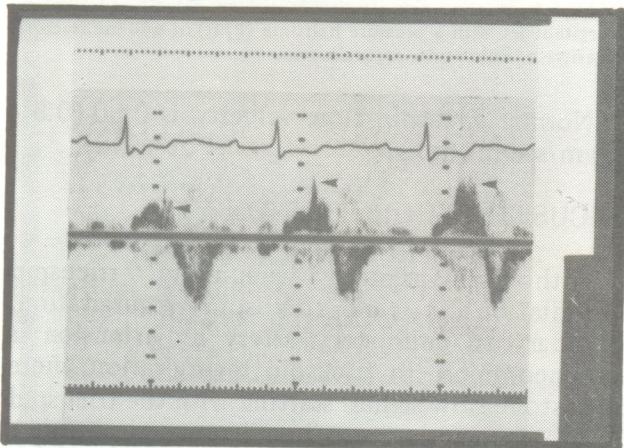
Pulsed wave Doppler tracing of hepatic vein (subcostal view) from the same patient. Note the prominent systolic reversal (arrow heads) suggestive of tricuspid regurgitation.
